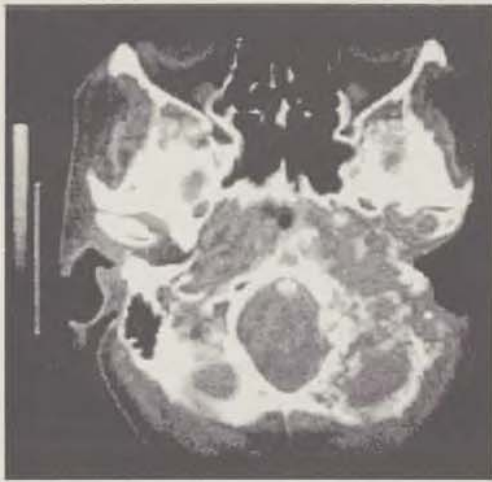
CT scan shows a skeletal destruction in the temporal region.
